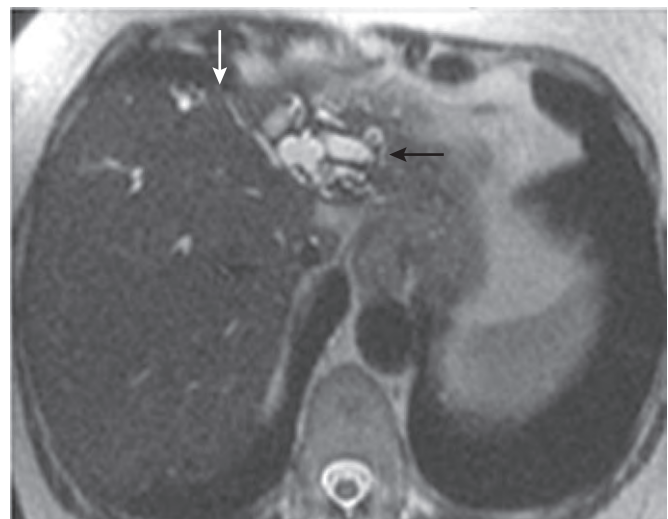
MRI appearance of hilar cholangiocarcinoma with lobar atrophy. Note the crowded, dilated ducts (*black arrow*) denoting the presence of small, hypoperfused left hepatic lobe (demarcated by the *white arrow*).
